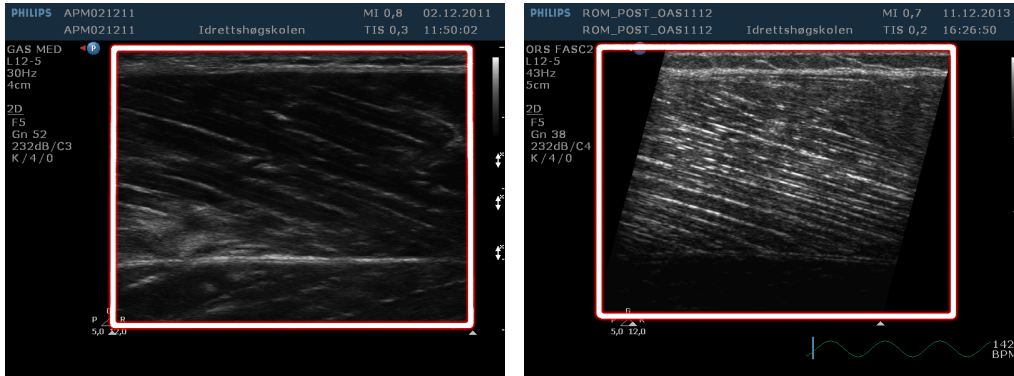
Images with the region of interest we hope to locate in the ultrasound images marked.
